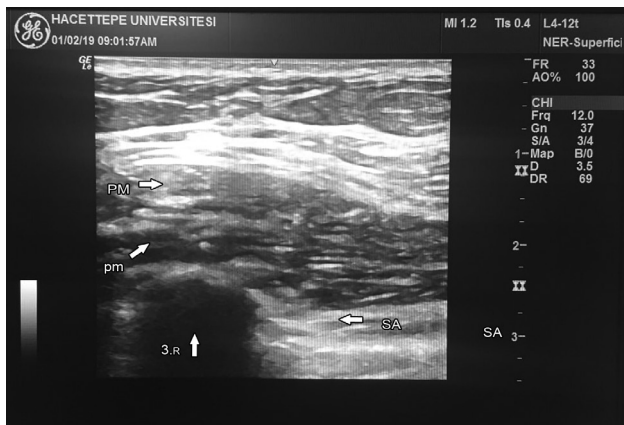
The ultrasound vision of pectoral major, pectoral minor and serratus anterior muscles. PM - pectoral major muscle, pm - pectoral minor muscle, 3.R - the third rib, SA - serratus anterior muscle
